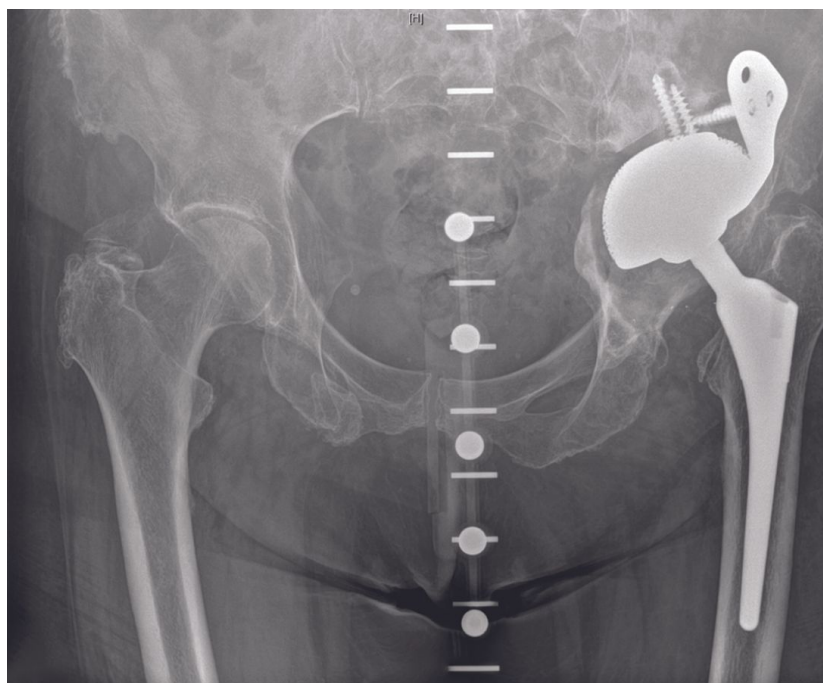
Preoperative radiograph showing a loose acetabular component with a Paprosky type 3B defect with pelvic discontinuity.
